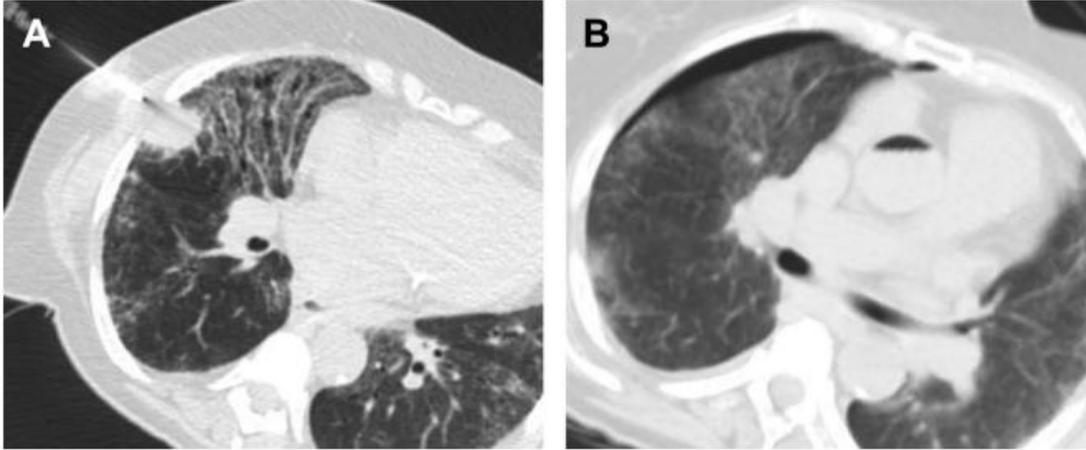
Axial CT scans of the chest showing a 60-year-old woman with air embolism after PTNB (A) Axial lung window CT image shows coaxial needle in the chest wall and a 2.5-cm middle lobe nodule. (B) Repeat CT after the patient's condition deteriorated shows a small right pneumothorax and air in the ascending aorta secondary to an air embolus.
